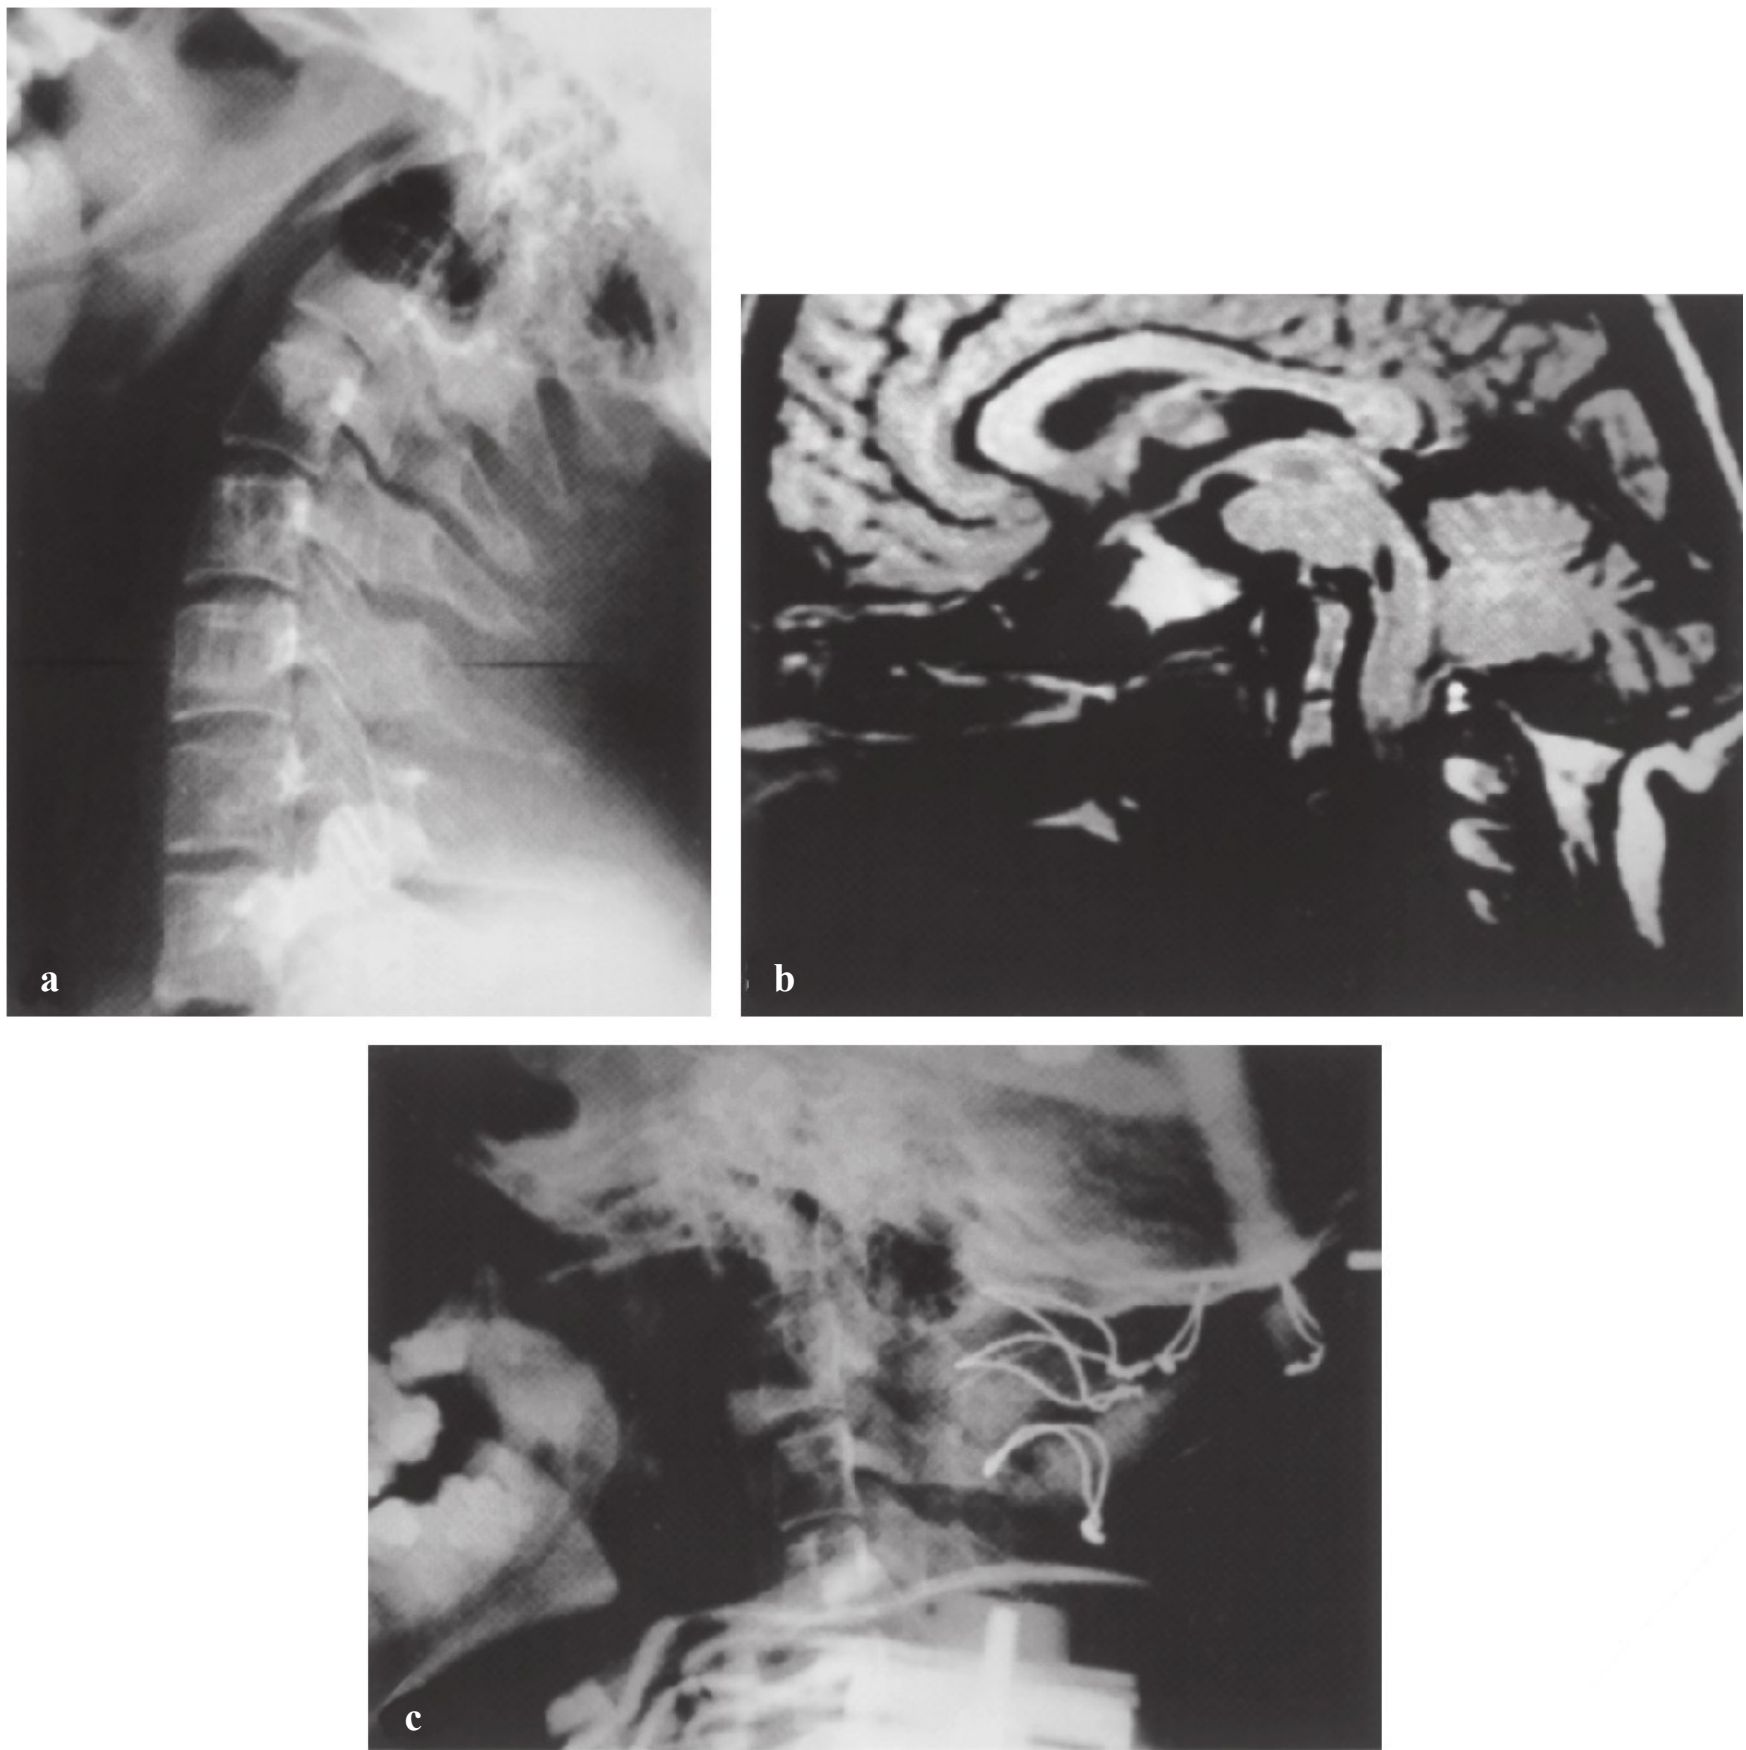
An 18-year-old man with osteogenesis imperfecta and basilar invagination presented with unrelenting headache, neck pain, and myelopathy. (a) Lateral radiograph demonstrating basilar invagination with the odontoid protruding into the foramen magnum. (b) Magnetic resonance imaging scan showing the odontoid indenting the brain stem. (c) Postoperative lateral radiograph showing a triple wire technique and posterior occipital–cervical fusion.
